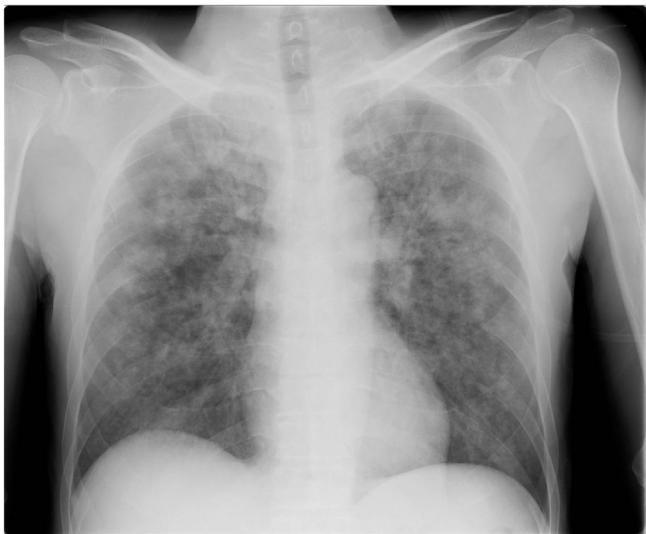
A chest X-ray obtained on admission showed diffuse infiltration throughout all lung fields.
